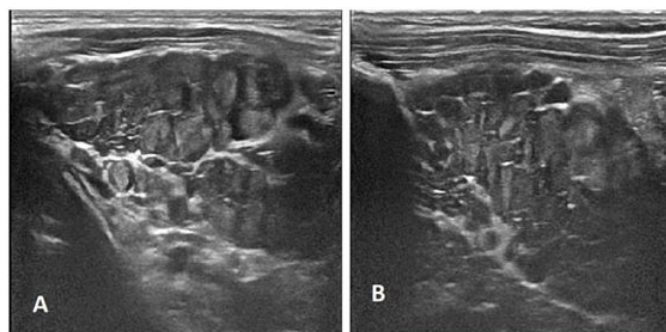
Ultrasound reveals neurofibromas in the form of heterogeneous nodular formations limited to the left supraclavicular region.
